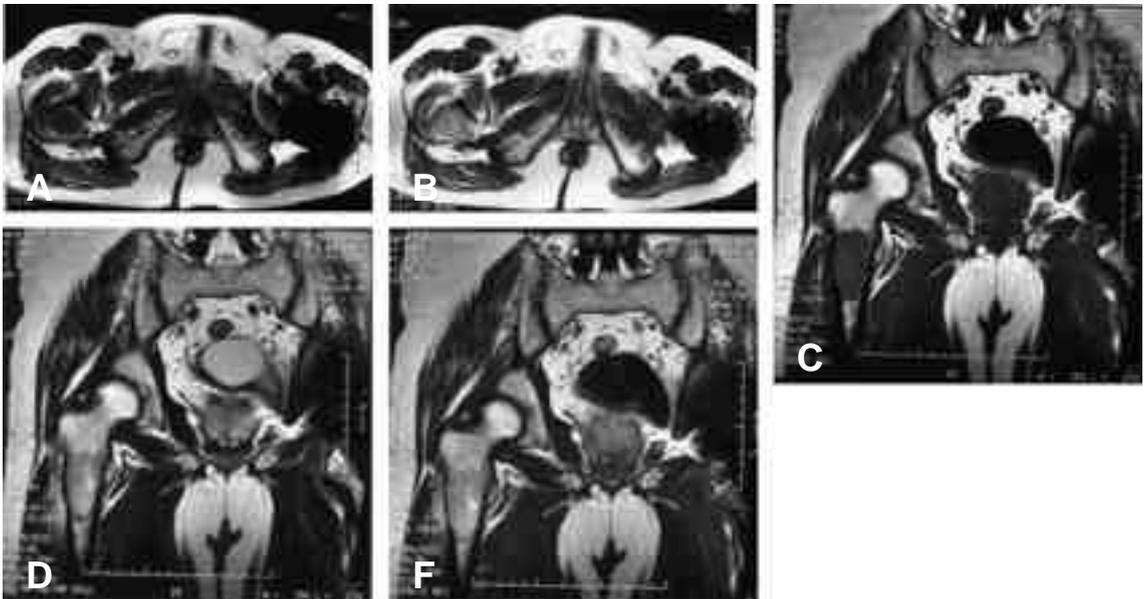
63 year-old-male. Renal cell cancer. Initial MRI before 2nd surgery
